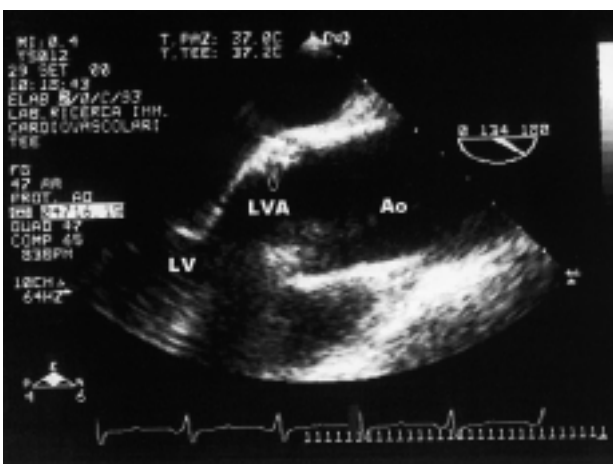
Transesophageal echocardiography after closure of the aneurysm with the pledget sutures. Abbreviations as in figure 2.
